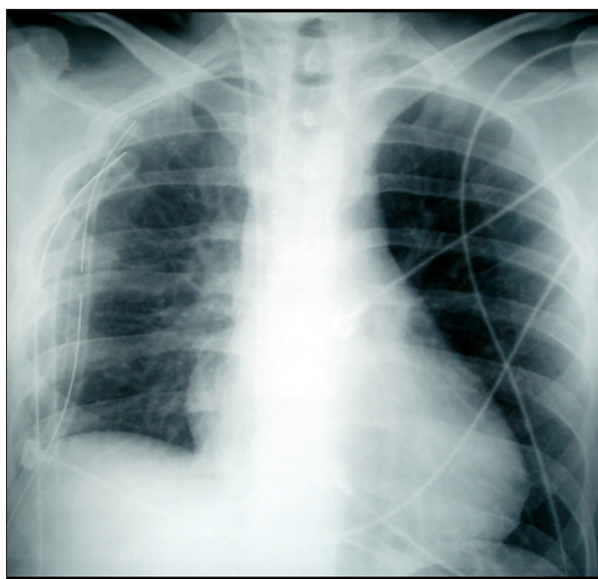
Postoperative chest X-ray showing complete expansion of both lungs without pneumothorax or pleural effusion. Chest drainage tubes are visible.
